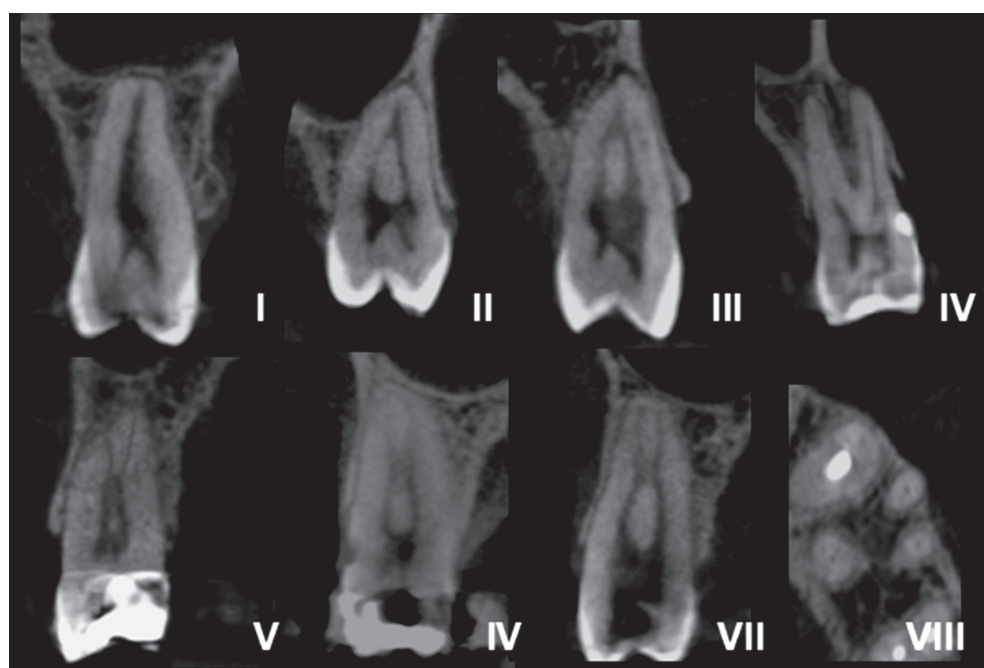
Vertucci classification types found in the present studies among the maxillary premolars assessed by CBCT. CBCT coronal sections showing Vertucci Classification from type I to VII and sagittal section showing type VIII classification
